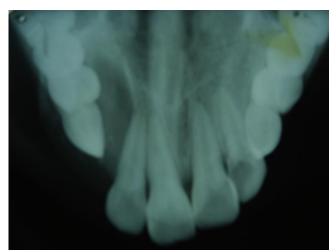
OCCLUSAL RADIOGRAPH SHOWING BICORTICAL EXPANSION WITH SCLEROTIC BORDERS
